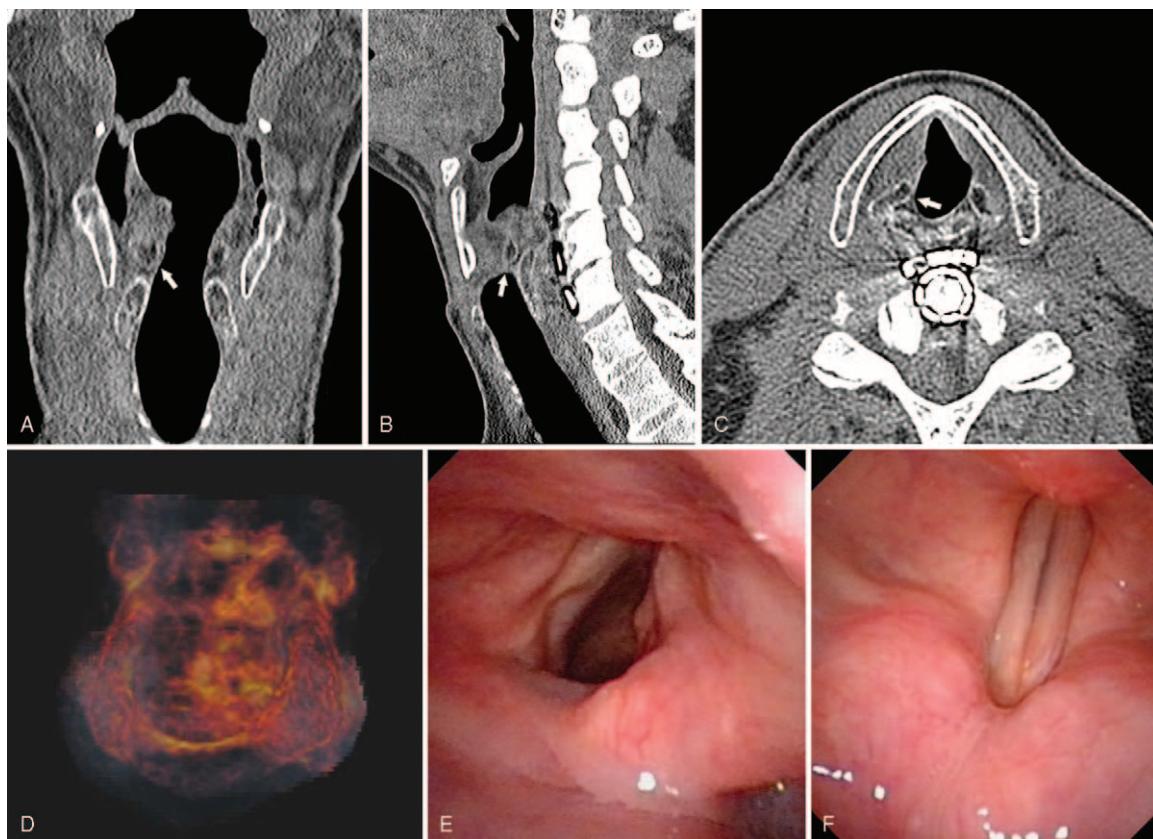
A: Coronal images of high-resolution CT scanning shows reduction of the right arytenoid cartilage. (As shown in the white arrow). B: Sagittal images of high-resolution CT scanning shows reduction of the right arytenoid cartilage. (As shown in the white arrow). C: Axial images of high-resolution CT scanning shows reduction of the right arytenoid cartilage. (As shown in the white arrow). D: Three-dimensional CT view shows symmetry in the joint space on both sides. E: Laryngoscopic view shows normal mobility of the right vocal fold. F: Laryngoscopic view shows normal closure of the right vocal fold.
